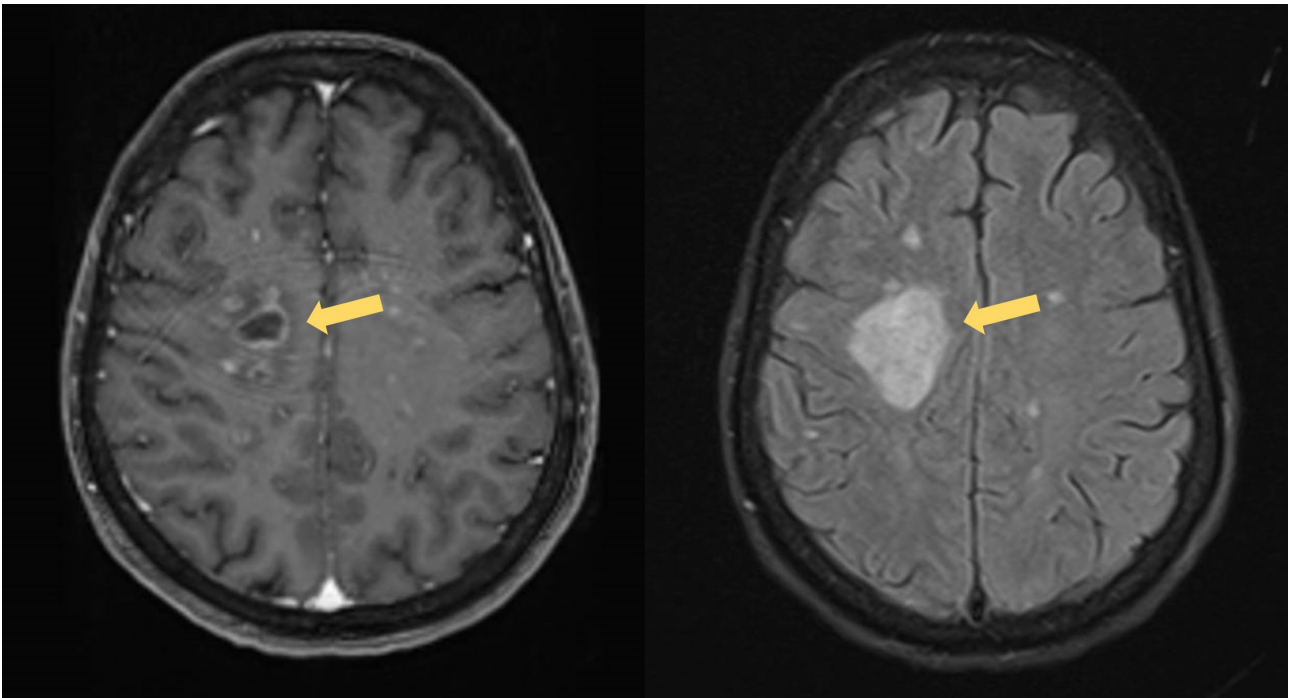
Brain MRI axial images. The T1-FS sequence (left) shows several small ring-enhancing parenchymal lesions, the largest one in the right centrum semiovale (arrow), also surrounded by a hypointense area. On the T2-FLAIR sequence (right), the lesions are hyperintense and have adjacent hyperintense areas of perilesional oedema (arrow).
